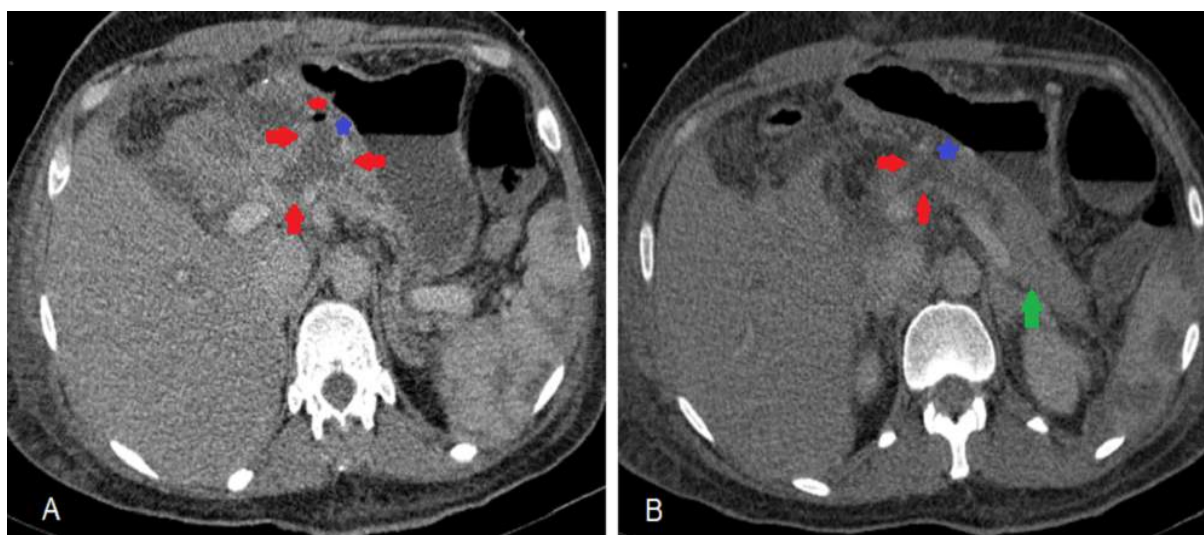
Abdominal and pelvic CT injected at portal phase in axial section (A and B) showing a collection (red arrow) with an air bubble (red star) opposite the pancreatic-gastric anastomosis (blue star) and the residual pancreas (green arrow) on the 5th postoperative day with a high amylase level in the drains
